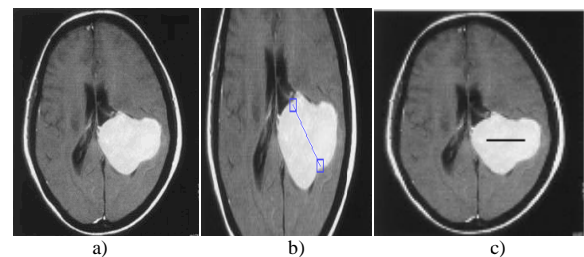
a) MRI image b) Rough diameter drawn by user c) User Interaction which get Computerized
